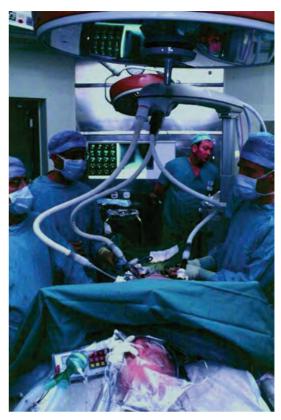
(a) Laparoscopic cryoablation of metastatic liver disease. (b) The ablation is monitored by laparoscopic contact ultrasonography – the expanding ice-ball has a hyperechoic margin that surrounds an acoustic shadow.
